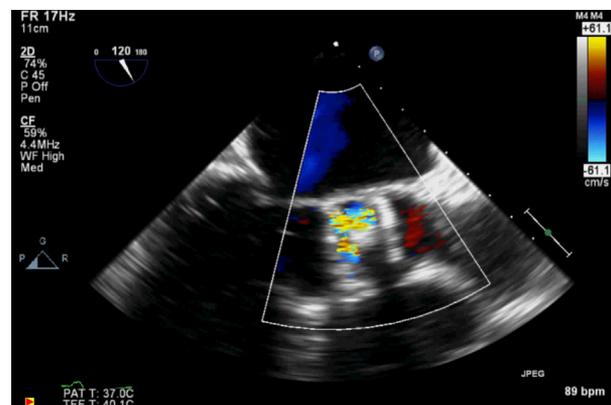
Postprocedure transesophageal echocardiography revealing the occluder device in proper position over the aortic valve. Utilizing color-flow Doppler, turbulence is seen within the discs, but no residual aortic insufficiency is present.
